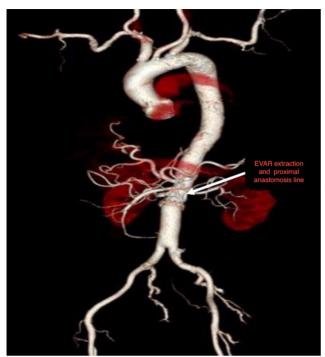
Computed tomographic image of the EVAR extraction and anastomosis line. EVAR: Endovascular aneurysm repair.
